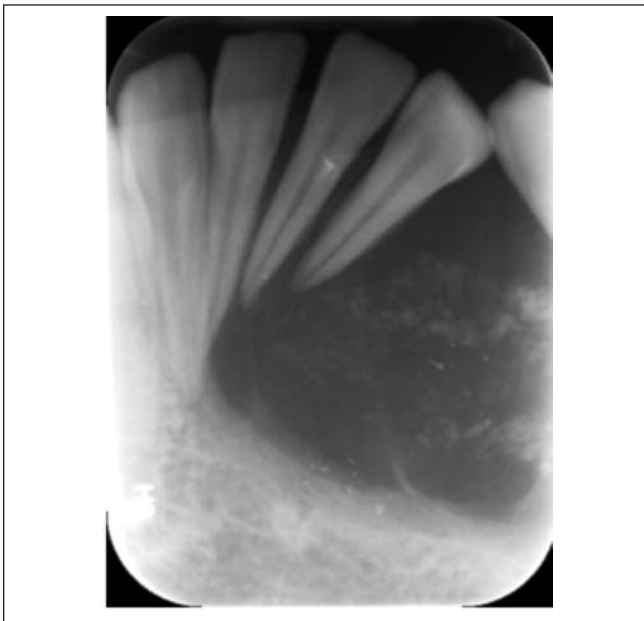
Periapical radiograph of left mandibular anterior region indicating a well defined radiolucency with multiple internal calcifications and displacement of #21, #22, #23 and #24.
